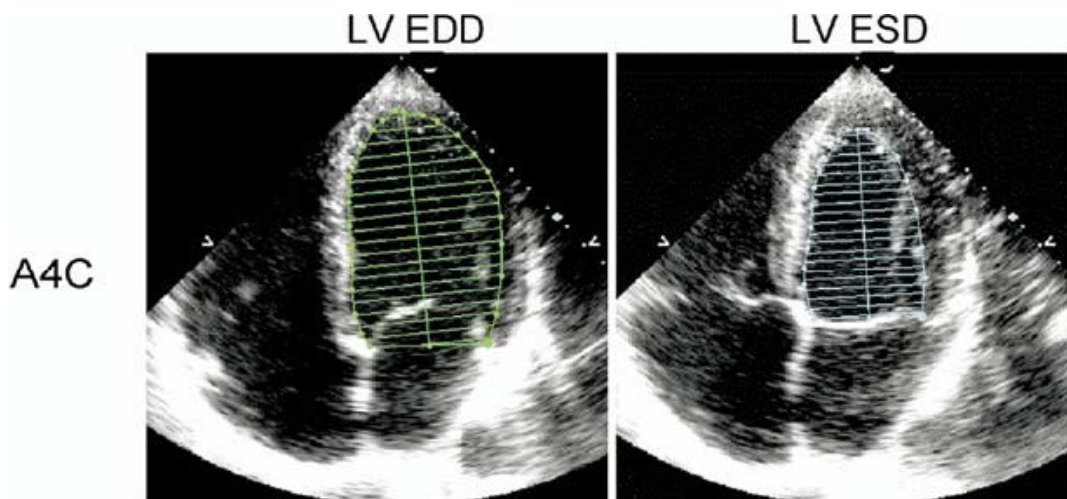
Modified Simpson's method of measuring EF (in apical 4 chamber views at end-systole and end-diastole) (Lang *et al.*, 2005).
